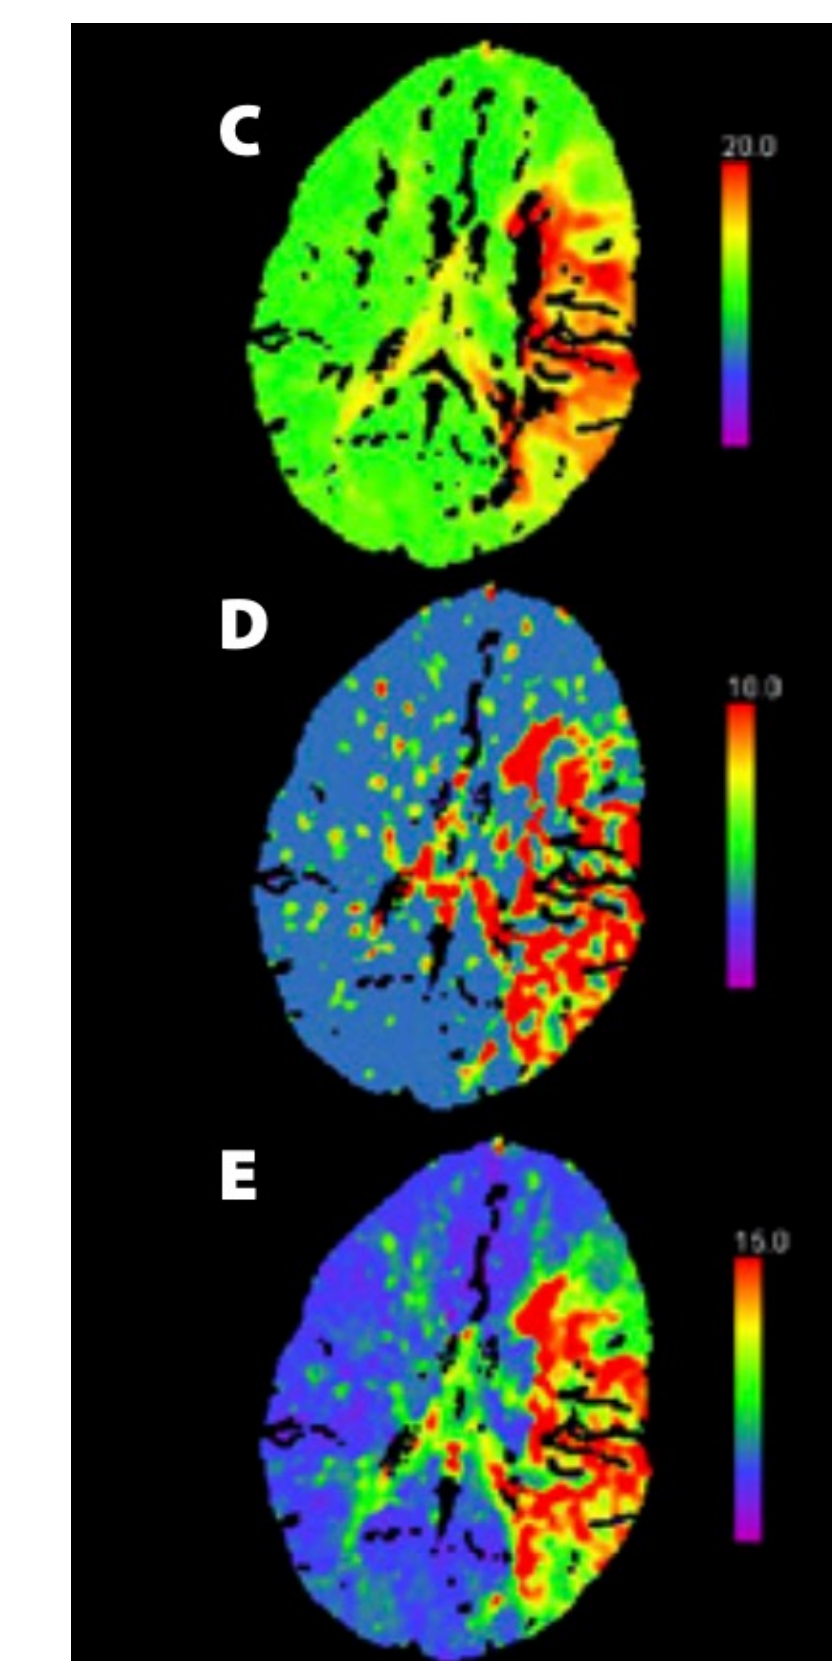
A CT perfusion study showing different functions.
